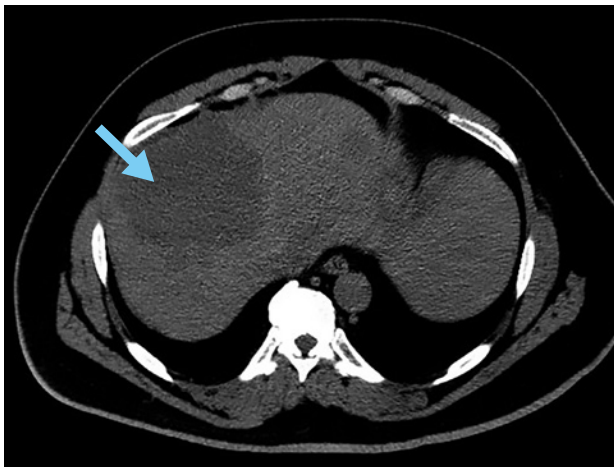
Computed tomography (CT) image showing a transverse slice, indicating a 12-cm liver tumor in the right lobe (arrow). Image courtesy of the authors.
